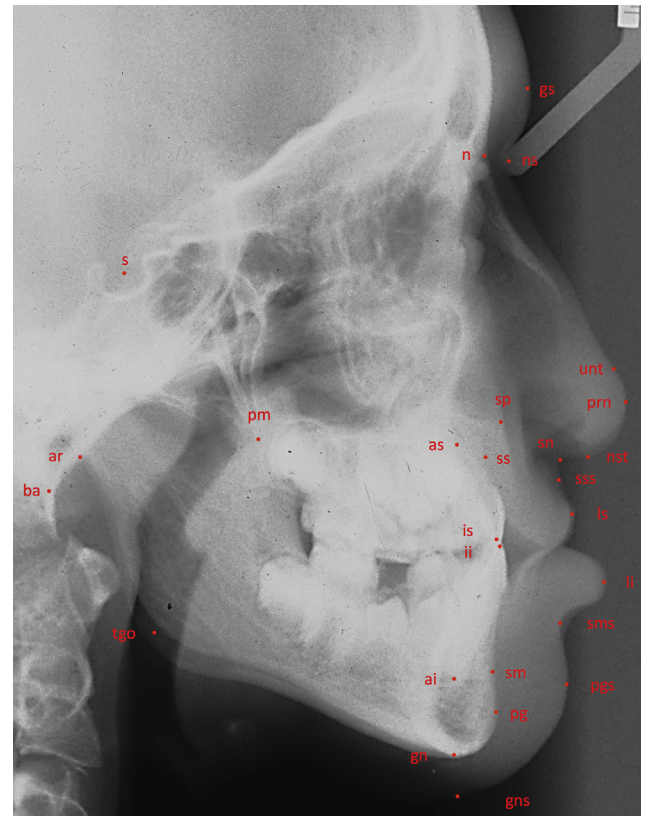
Reference points and lines on lateral cephalometric radiograph. *Hard tissue reference points:* ai, apex inferius (the apex of the root of the most prominent lower central incisor); ar, articulare (the point at the intersection between the contours of the mandibular ramus and the occipital bone); as, apex superius (the apex of the root of the most prominent upper central incisors); ba, basion (the most posterior–inferior point on the clivus bone); gn, gnathion (the most inferior point on the mandibular symphysis); ii, incision inferius (the incisal edge of the lower most prominent incisor); is, incision superius (the incisal edge of the most prominent upper incisor); n, nasion (the most anterior point of the frontonasal suture); pg, pogonion (the most anterior point on the mandibular symphysis); pm, pterygo-maxillare (the intersection of the nasal floor and the posterior contour of the maxilla); s, sella (the center of the sella turcica); sm, supramentale (B-point; the deepest point on the anterior contour of the lower anterior process); sp, spina nasalis anterior (the apex of the anterior nasal spine); ss, subspinale (A-point; the deepest point on the anterior contour of the upper alveolar arch); tgo, gonion tangent point (the point of intersection between the mandibular line and the ramus line). *Soft tissue reference points:* gs, soft tissue glabella (the most anterior point on the soft tissue glabella); gns, soft tissue gnathion (the soft tissue point overlying gn); li, labrale inferius (the most prominent point on the prolabium of the upper lip); ls, labrale superius (the most prominent point on the prolabium of the upper lip); nst, soft tissue nasion (the deepest point on the frontonasal curvature); nst, nasal septum tangent point (the anterior tangent point to the tangent to the nasal septum through sn); pgs, soft tissue pogonion (the most prominent point on the chin); prn, pronasale (the most prominent point on the apex of the nose); sms, soft tissue supramentale (the point of the greatest concavity in the midline of the lower lip); sn, subnasale (the deepest point in the nasolabial curvature); sss, soft tissue subspinale (the point of greatest concavity or convexity in the midline of the upper lip); unt, upper nasal tangent point from ns. *Skeletal reference lines:* Ili, axis of lower incisors (a line from ii to ai); IIs, axis of upper incisors (a line from is to as); ML, mandibular line (the tangent to the lower border of the mandible through gn); NL, nasal line (the line through sp and pm); NSL, nasion-sella-line (the line through n and s). (From Brattström et al., 2005; modified.)
